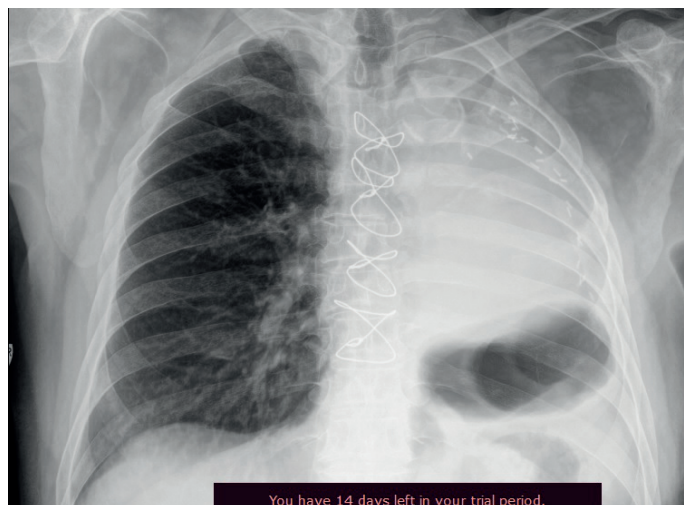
Postoperative lung x-ray image
